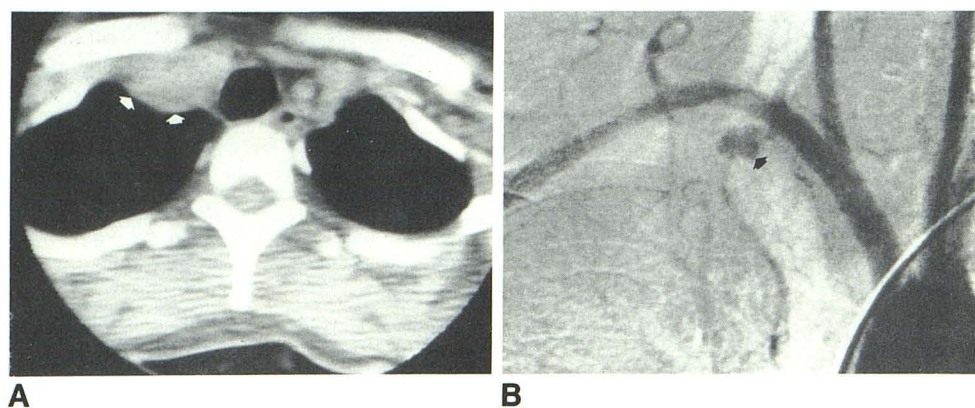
A. CT shows right retroclavicular mass (arrows) in region of right subclavian artery and brachiocephalic vein. B. IV digital subtraction angiogram shows pseudoaneurysm of proximal right internal mammary artery (arrow). Larger size of mass seen on CT is explained by surrounding hematoma.
